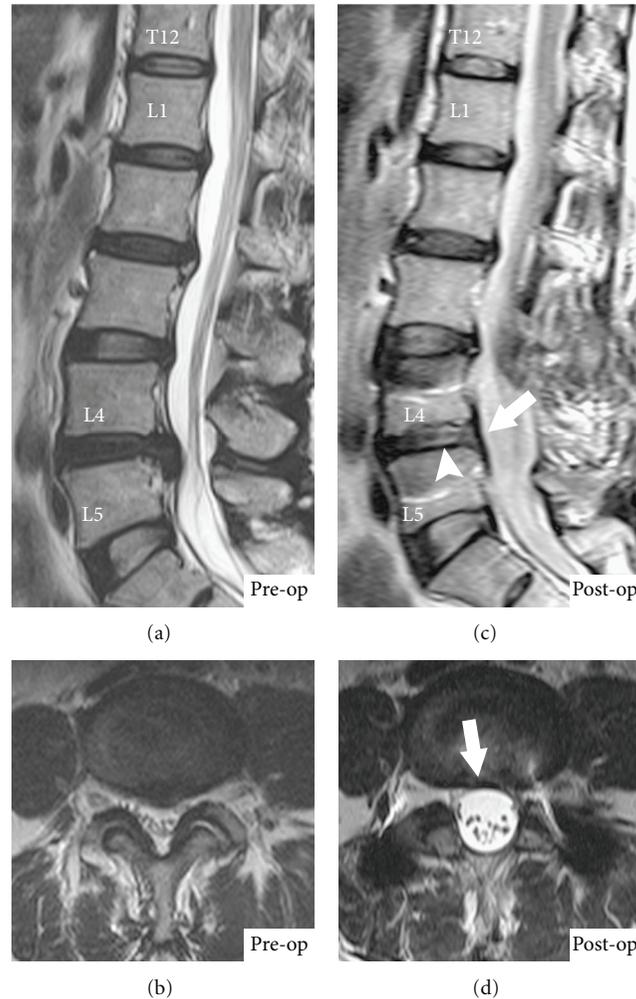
MRI T2-weighted image of a 56-year-old female. ((a) and (c)) Sagittal view. ((b) and (d)) Axial view. The significant increase in CDS was seen in L4-5 level (preoperative 0.44 to postoperative 0.92) at 24-month followup. Meanwhile, the signal intensity of T12-L1 demonstrated to be similar brightness. Arrow, reduced bulging disc after stabilization; arrowhead, significant increase in CDS.
